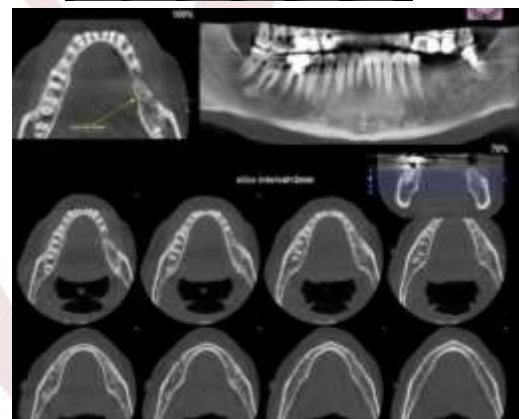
View of incomplete socket healing with highly diffused trabeculae and sclerotic tissue in CBCT images.
